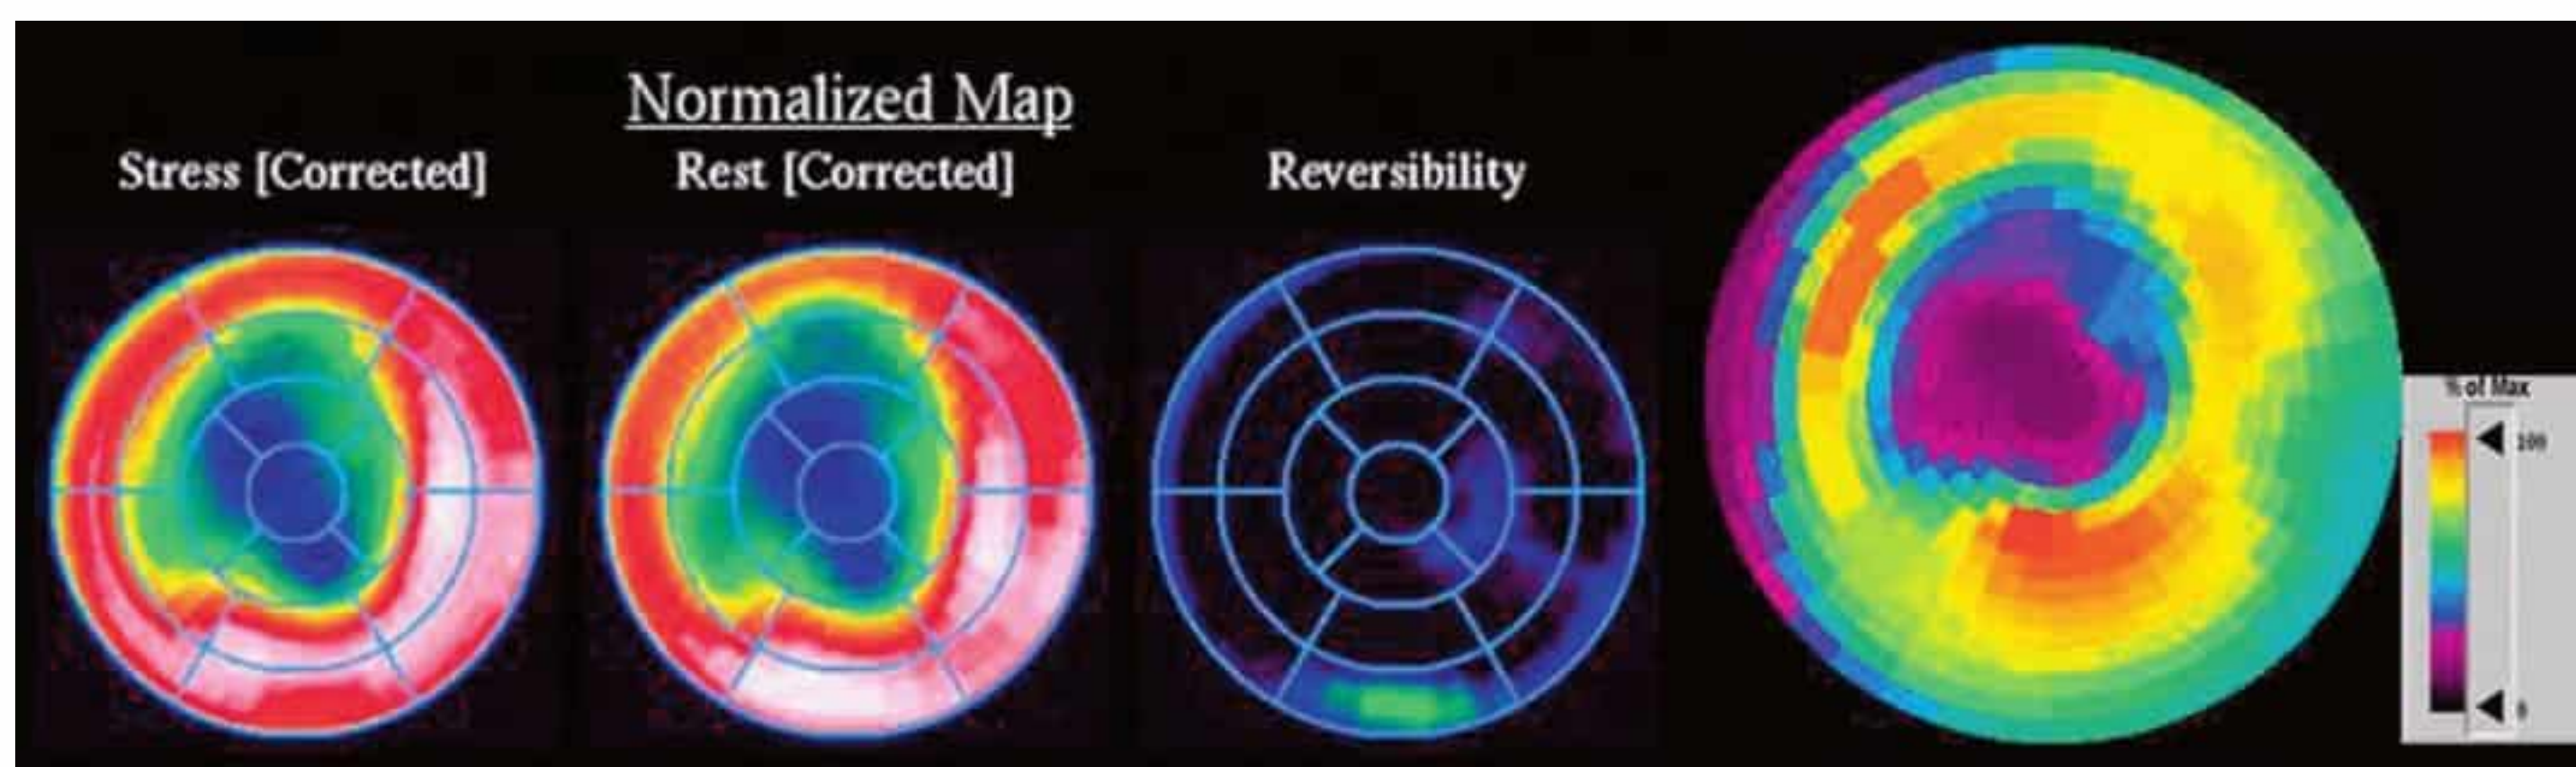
Example of a myocardial scar (fixed, irreversible area of decreased uptake with no evidence of viability on [18F]FDG-PET) on the cardiac apex and adjacent portions of the posterior and anterior walls and periapical septal wall.
